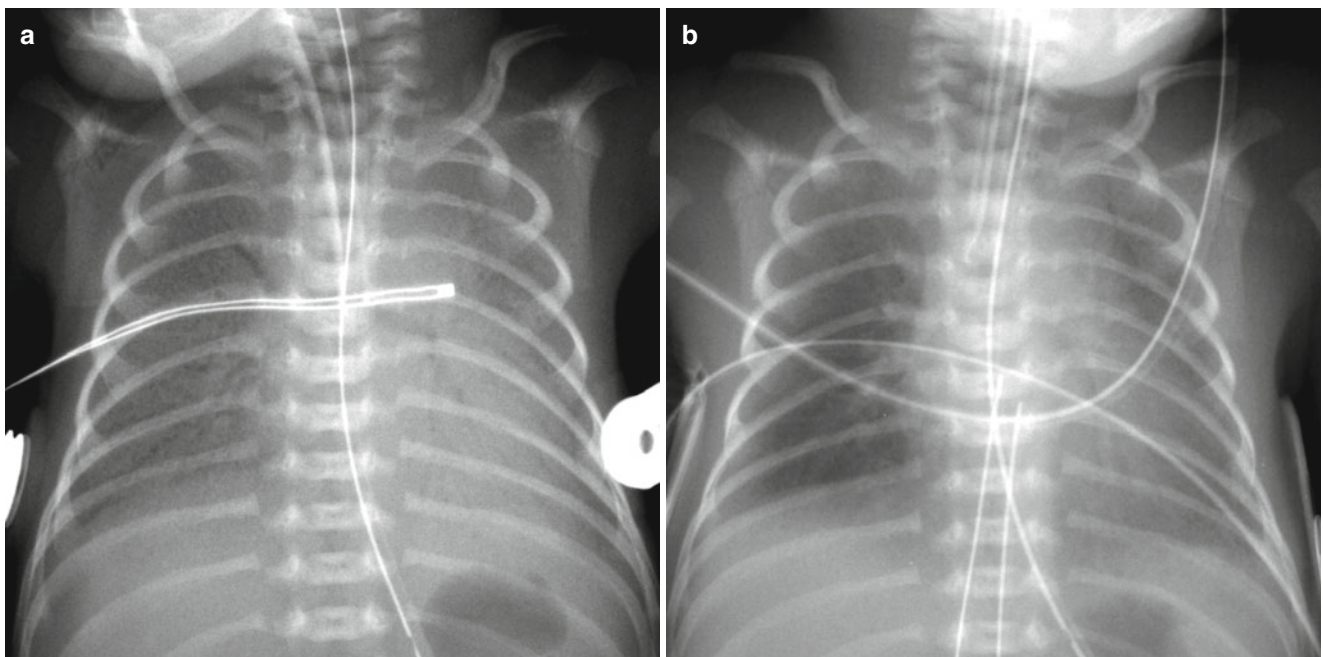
Hyaline membrane disease in a premature neonate of 28 weeks’ gestational age. (a) Anteroposterior chest radiograph obtained on the first postnatal day demonstrates diffuse fine granularities, pulmonary hypoventilation, and air bronchograms. (b) Follow-up
